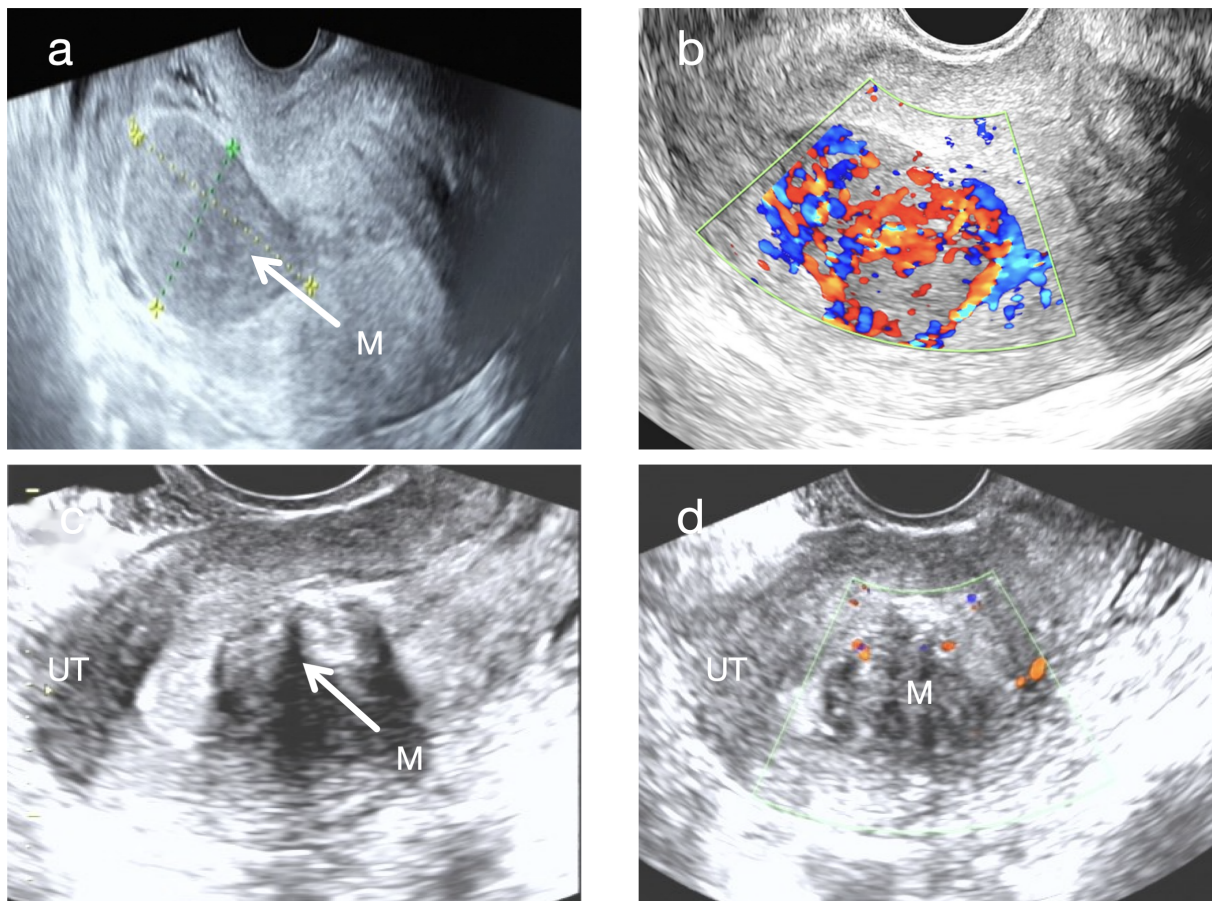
Comparison of sonographic images between submucosal UIMT (Case 1) and typical submucosal uterine leiomyoma. (a) Sagittal ultrasonographic view of the submucosal UIMT mass. White arrows indicate the tumor masses. (b) CDFI showing abundant blood flow signals within the submucosal UIMT mass (Adler grade 3) with a “colorful mosaic sign”. (c) Sagittal ultrasound view of a typical submucosal uterine leiomyoma. White arrows indicate the tumor masses. (d) CDFI showing sparse blood flow signals in the typical submucosal uterine leiomyoma (Adler grade 1).
